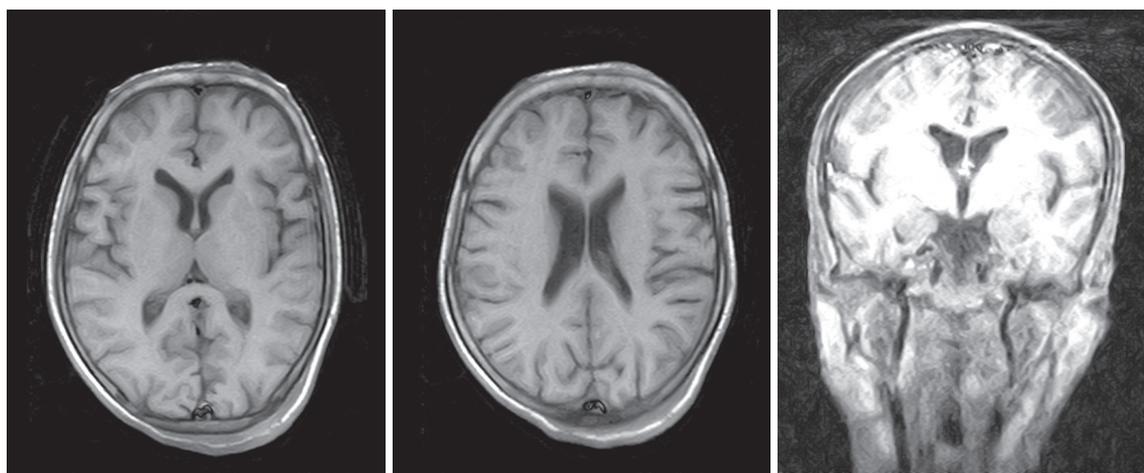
MRI of the patient
